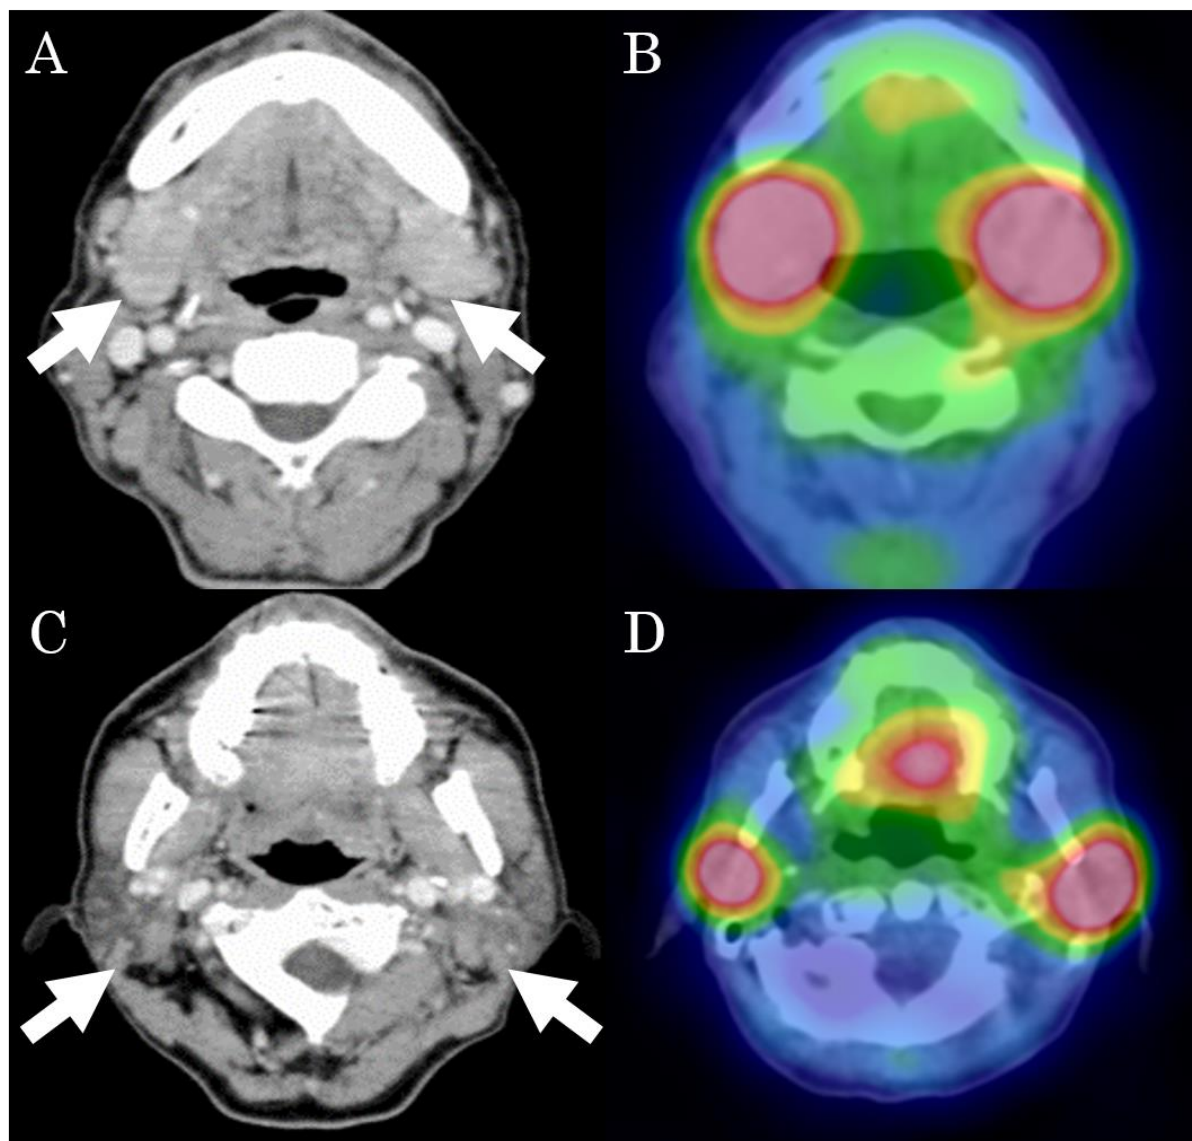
Contrast-enhanced CT shows slight enlargement of the submandibular (A, arrows) and parotid (C, arrows) glands. A ^{67}Ga SPECT/CT shows abnormal uptakes in each gland (B, D).
